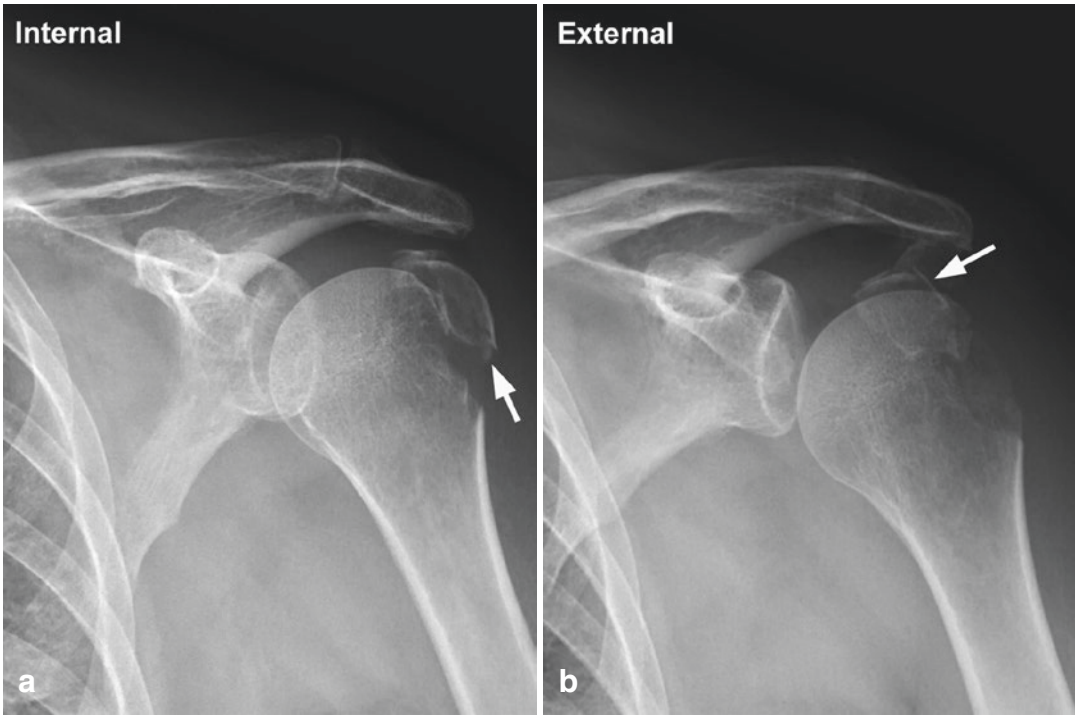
AP radiographs obtained in internal rotation (a) and external rotation (b) show a displaced fracture of the posterior aspect of the greater tuberosity (arrow)
